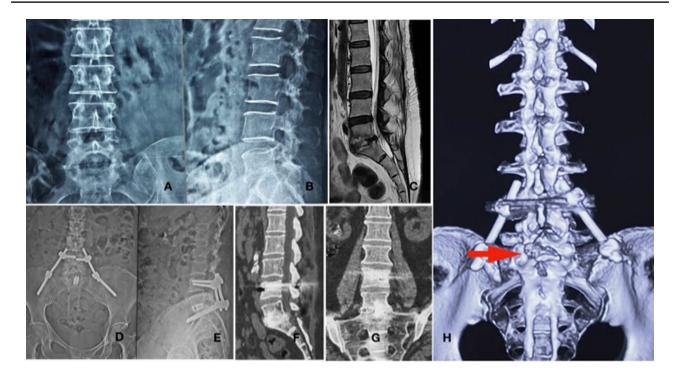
Plain AP radiograph of lumbosacral spine (a) showing destruction of left S1 pedicle and lateral radiograph (b) showing collapsed L5–S1 disk space with bony end plate erosion. T2W MRI (c) showing L5–S1 spondylodiscitis and postoperative AP (d) and lateral radiograph (e) following short-segment stabilization with iliac screws
